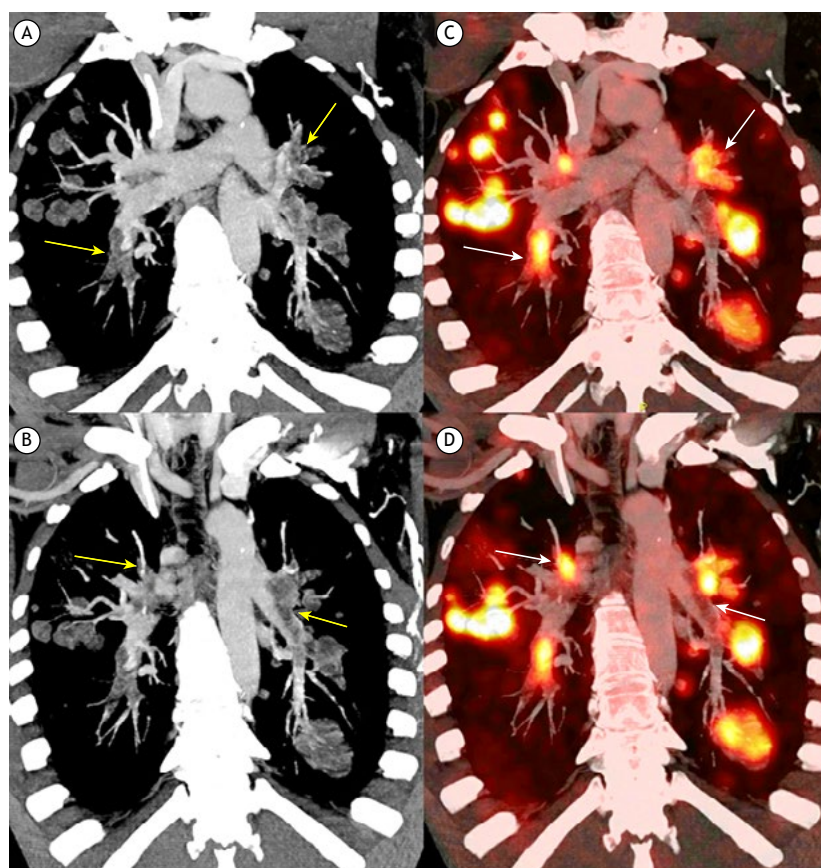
In A and B, coronal oblique maximum intensity projection CT reformations show the extent of the intravascular filling defects (yellow arrows). While the more expansive and nodular defects are easily seen as tumor lesions, those confined to the intravascular space are more difficult to differentiate from non-tumor thromboembolism. In C and D, coronal oblique fused PET/CT images demonstrate the extent of FDG hypermetabolism (white arrows). The fused images can separate the filling defects that have no FDG avidity and are therefore non-tumor lesions from those that show significant hypermetabolism indicating intravascular tumor embolism.
